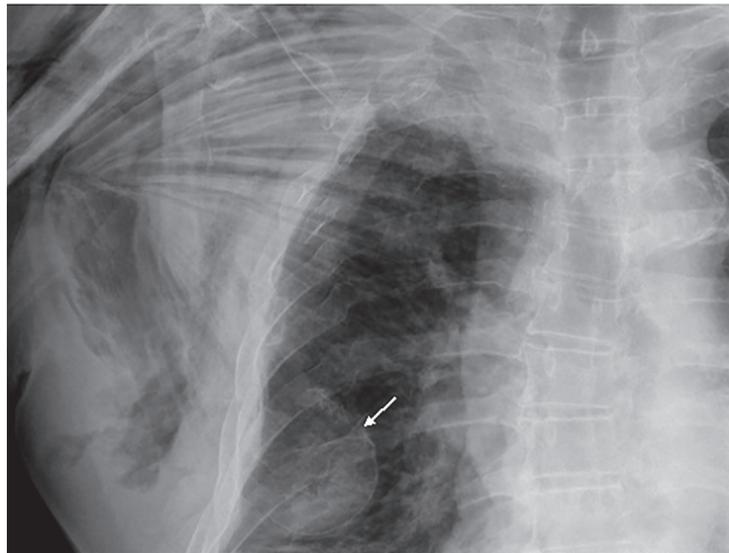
Chest radiography with the suspect opacity in the right subfield of the lung (arrow).
